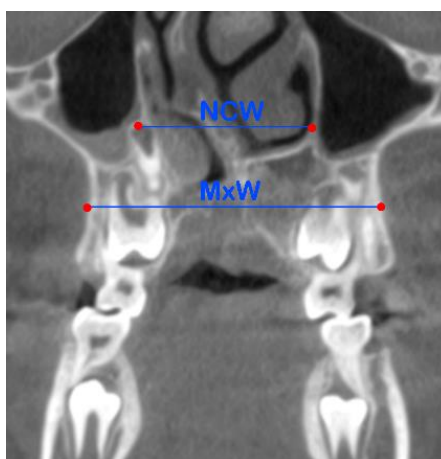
Cone beam computed tomography (CBCT) coronal slice at the first molar region transversal dimensions. The meaning of each abbreviation is described below: NCW—nasal cavity width—width of the nasal cavity measured at the level of the intersection between nasal cavity and maxillary sinus floor. MxW—maxillary width—maxillary width at the level of the hard palate. ACW—alveolar crest width—maxillary width at the level of the interpalatal alveolar crests. AW—arch width—dental arch width measured at the level of the palatal cusp tips. ACL—alveolar crest level—the buccal alveolar bone crest level was measured as the distance between the mesiobuccal cusp tip of the first permanent molar and the buccal alveolar bone crest. Molar
